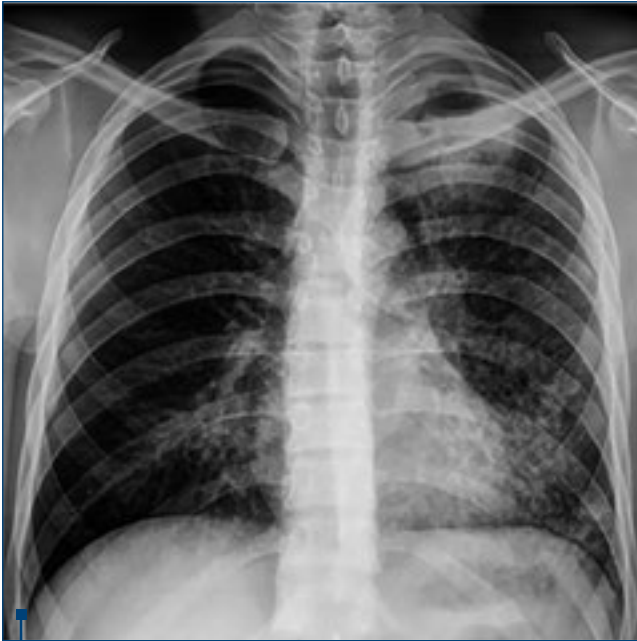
Initial chest x-ray with a diffuse left micronodular lung infiltrate and a left upper lobe cavity
